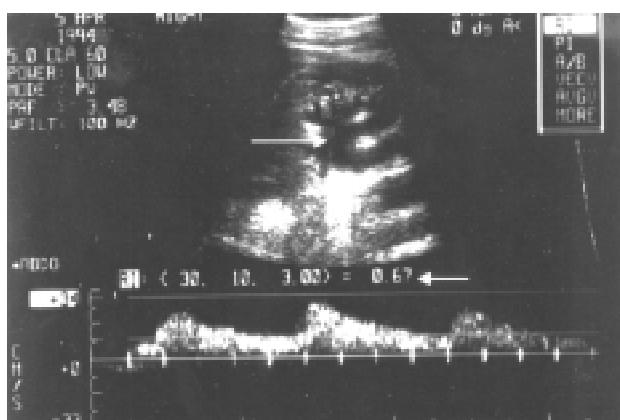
Doppler ultrasound shows a normal resistive index of 0.67 (arrow) in the face of obstruction and hydronephrosis (long arrow), demonstrating the unreliable nature of the resistive index for diagnosis of obstruction.
